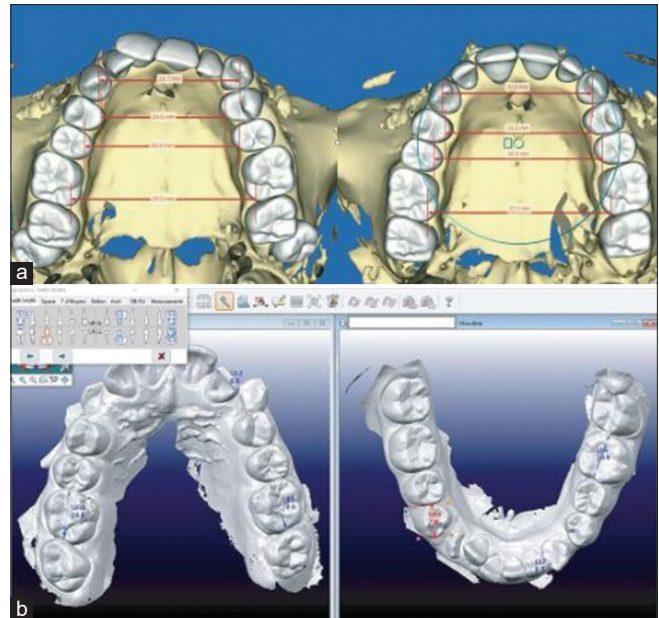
Digital reconstructions of dentures, based on (a) cone-beam computed tomography and (b) intraoral scans^[31]
